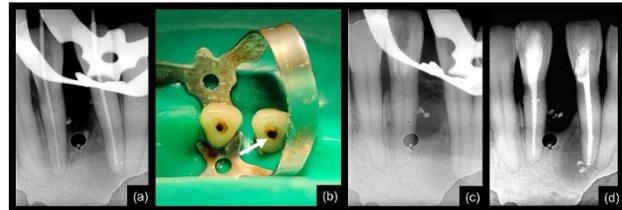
(A) Periapical radiograph showing the master apical fit of gutta-percha cone. (B and C) Clinical and radiographic presentation of sealed cervical perforation in relation to 41. (D) Postoperative periapical radiograph showing obturation of 31 and 41.
